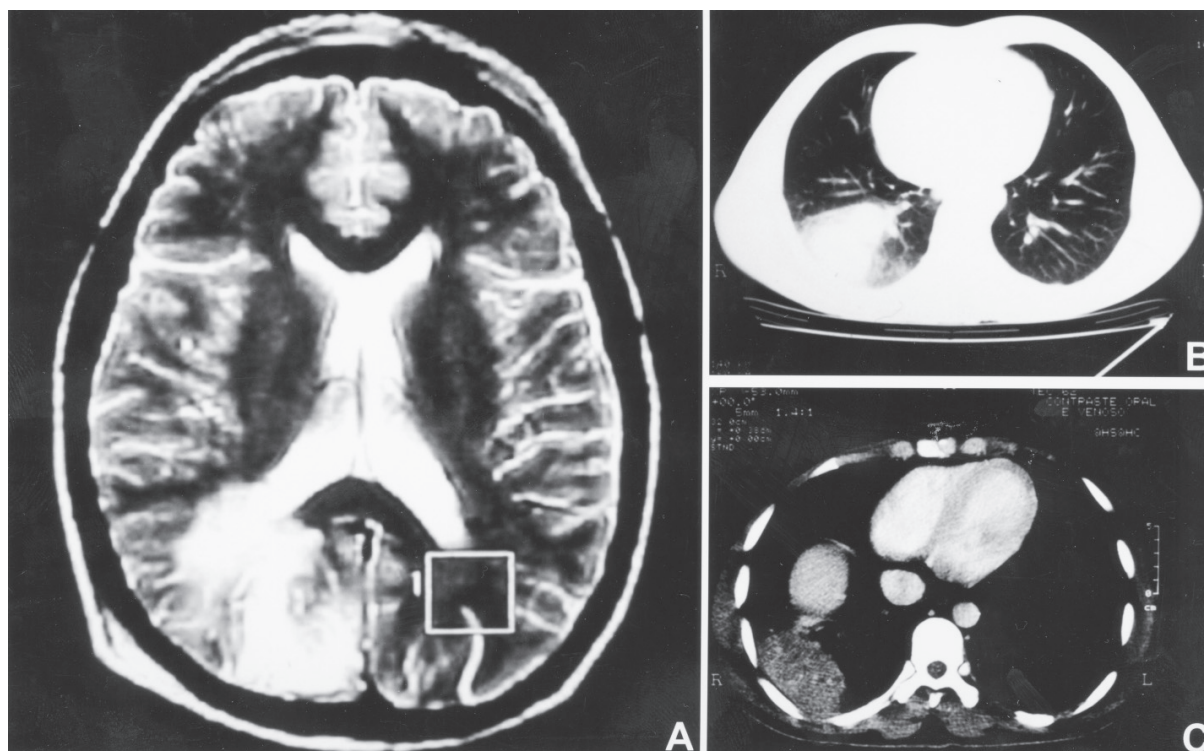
A - (MRI) - T2 weighted hypersignal in the right temporo-occipital region extending from the superficial cortex up to the ventricular wall. Note the obstruction of the adjacent sulcus suggesting edema. Attenuated small image involving the left temporo-occipital area (box). Magnetic resonance transversal image (6-mm thick) at the lateral ventricle level. B - Nodular opacity in the basal segment of the right inferior lobe of the lung. C - Soft tissue attenuated mass reveals a heterogeneous enhancement after intravenous contrast (mediastinal window).
